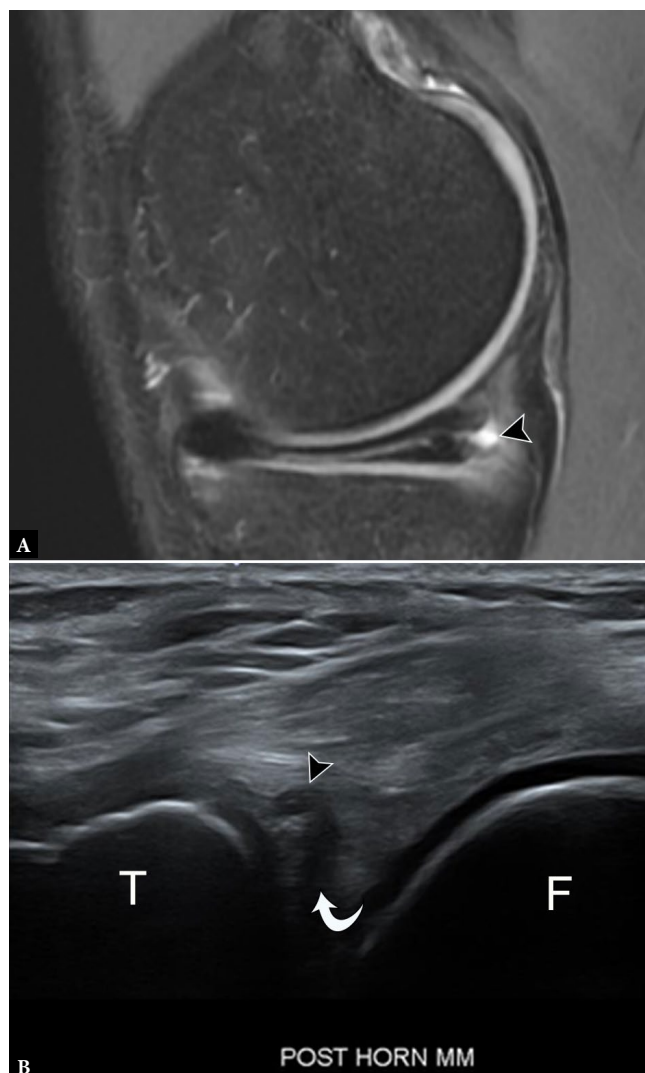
37-year-old male with horizontal meniscal tear and small parameniscal cyst. A. Sagittal proton-density-weighted fat-suppressed MR image demonstrates horizontal tear extending from the free edge of the medial meniscus to the periphery, with associated parameniscal cyst (arrowhead). B. Longitudinal grayscale US image of the posterior knee shows a horizontally oriented, hypoechoic cleft, consistent with a tear (curved arrow), in the echogenic, triangular posterior meniscus with a small, contiguous parameniscal cyst (arrowhead). T – tibia, F – femur
